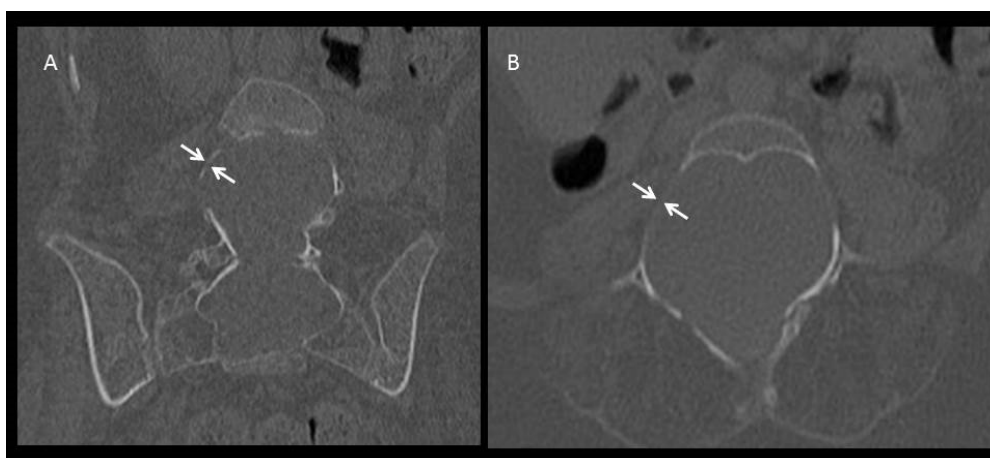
Coronal (A) and axial (B) CT images of the L5 vertebra showing severe thinning of the pedicle (white arrows).
